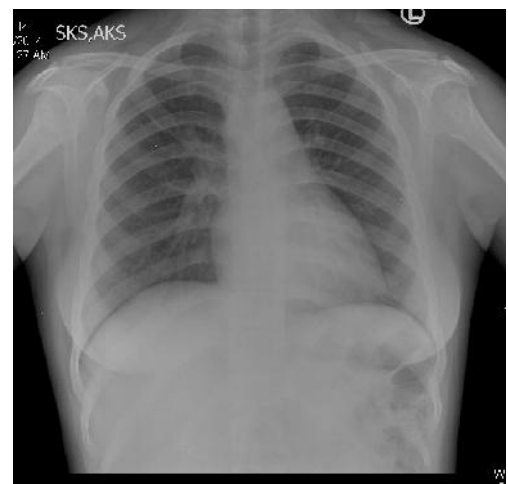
Chest radiograph of a SCD patient with ACS who had pericardial effusion with chest infiltrations and subsequently improved with treatment.
